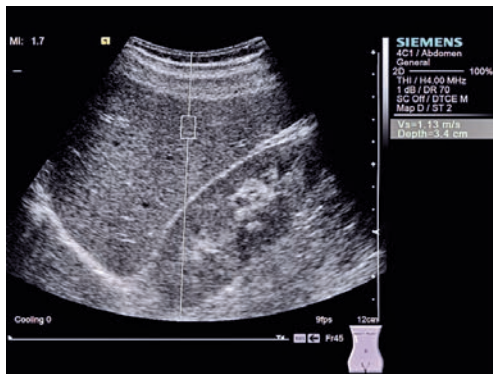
Ultrasound ARFI measurement in the liver acquired from the right intercostal space
